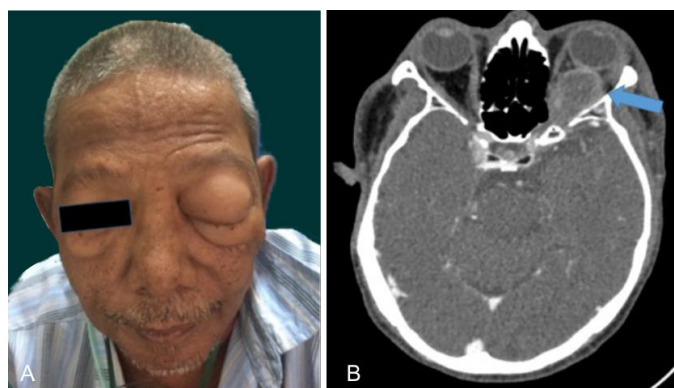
(A) Left eye proptosis. (B) Brain axial CT scan shows left intra-ocular mass (pointed by the blue arrow)
